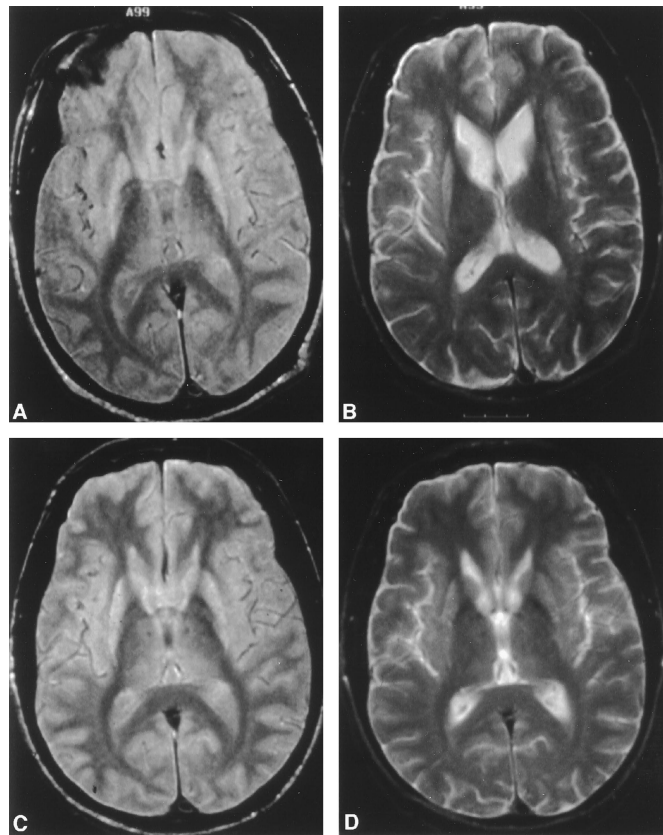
Representative sections through the striatum. Proton density-weighted images (PDWI) are on the left, and T2-weighted images are on the right. (A and B) Results of a study performed in 1998. (C and D) Similar sections from a study performed in 1995. Seen on both sets of images, but more clearly on the PDWI, is abnormal signal intensity in the putamen and caudate, reported in some cases of Huntington's disease. The apparent atrophy of the heads of the caudates (B) is caused by the cut of the section.
